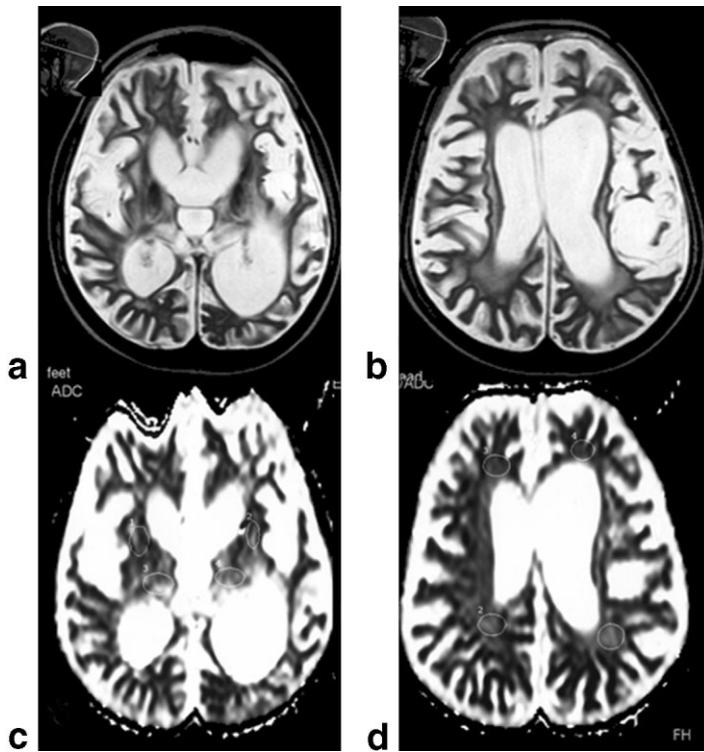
Findings in a 10-year-old boy with stage III SSPE. a and b: Axial T2-weighted image (TR = 4530 msec, TE = 100 msec) shows hyperintensities in the periventricular white matter, basal ganglia, and thalamus, with marked cerebral atrophy. c and d: ADC maps reveal high ADC values in the basal ganglia (1352 and $1376 \times 10^{-6} \text{mm}^2/\text{sec}$), thalamus (1678 and $1631 \times 10^{-6} \text{mm}^2/\text{sec}$), and periventricular white matter (1613 , 1634 , 1684 , and $1695 \times 10^{-6} \text{mm}^2/\text{sec}$).
